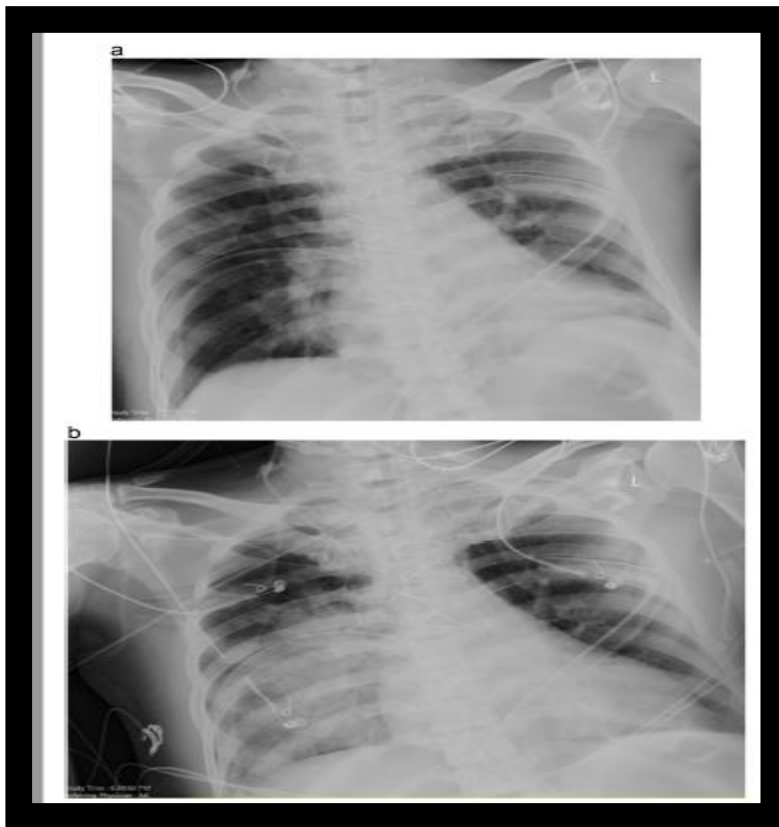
control chest X-ray confirmed its correct position
